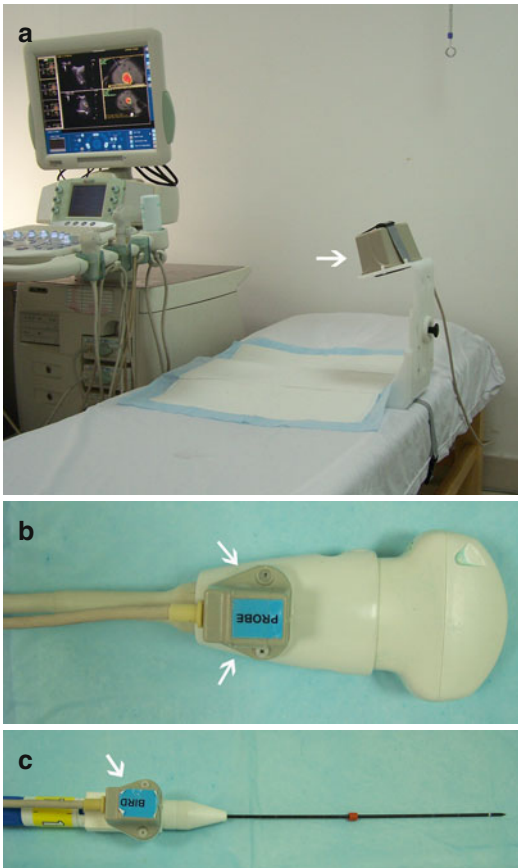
(a) A real-time virtual navigation system. The transmitter is fixed to the operation bed (*arrow*). (b) A magnetic sensor is applied to the sonographic probe (*arrow*). (c) A magnetic sensor is mounted on the microwave (MW) antenna
